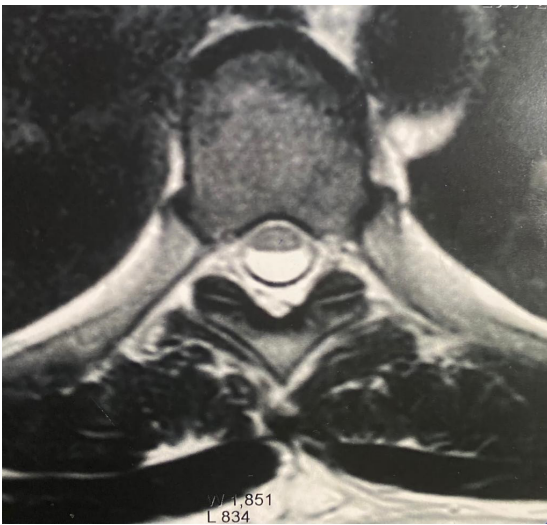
The Preoperative Magnetic Resonance Image: One can observe a widened area of the dorsal subarachnoid space of the vertebral channel at the height of the distal portion of the T7 vertebral body, compressing the posterior surface of the marrow. It measures about 2 cm in caudal cranium diameter. There is even a signal alteration in the marrow because of probable compression.
